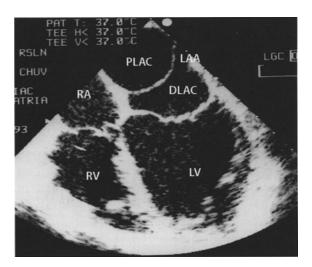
Cor triatriatum: echocardiography. Transesophageal echocardiography showing the membrane dividing the left atrium into two chambers: the proximal chamber (superior and posterior) collecting the pulmonary veins and the distal chamber (inferior and anterior) with the left auricular appendage and the mitral valve (*DLAC* distal left atrial chamber, *LAA* left auricular appendage, *LV* left ventricle, *PLAC* proximal left atrial chamber, *RA* right atrium, *RV* right ventricle) (photograph courtesy of Dr. Pierre-Guy Chassot)
